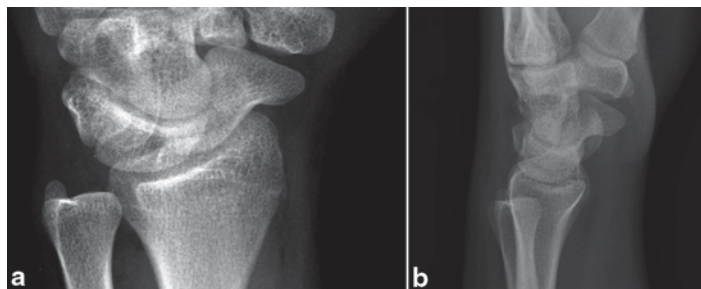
An oblique radiograph a and lateral radiograph b obtained a day after the patient's injury. No true *AP* view was obtained. It is difficult to definitively identify a fracture line on these radiographs. (Published with kind permission of ©Megan Tomaino and Thomas B. Hughes, 2015. All rights reserved)
